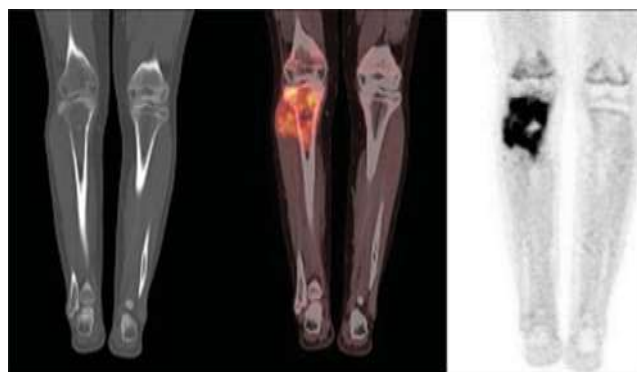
PET/CT scan findings in osteosarcoma.
